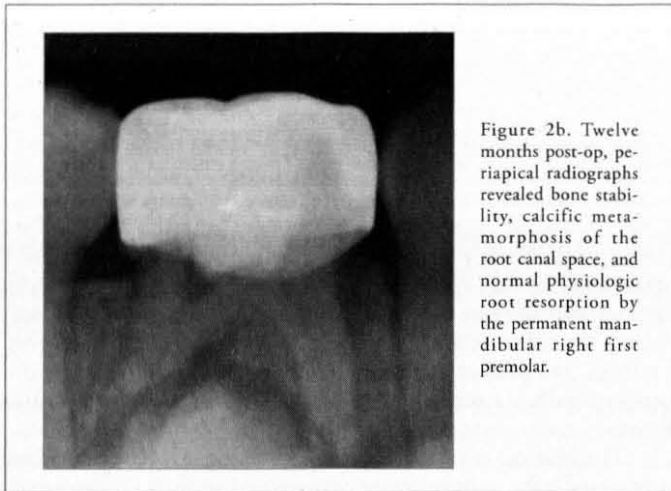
Twelve months post-op, periapical radiographs revealed bone stability, calcific metamorphosis of the root canal space, and normal physiologic root resorption by the permanent mandibular right first premolar.
